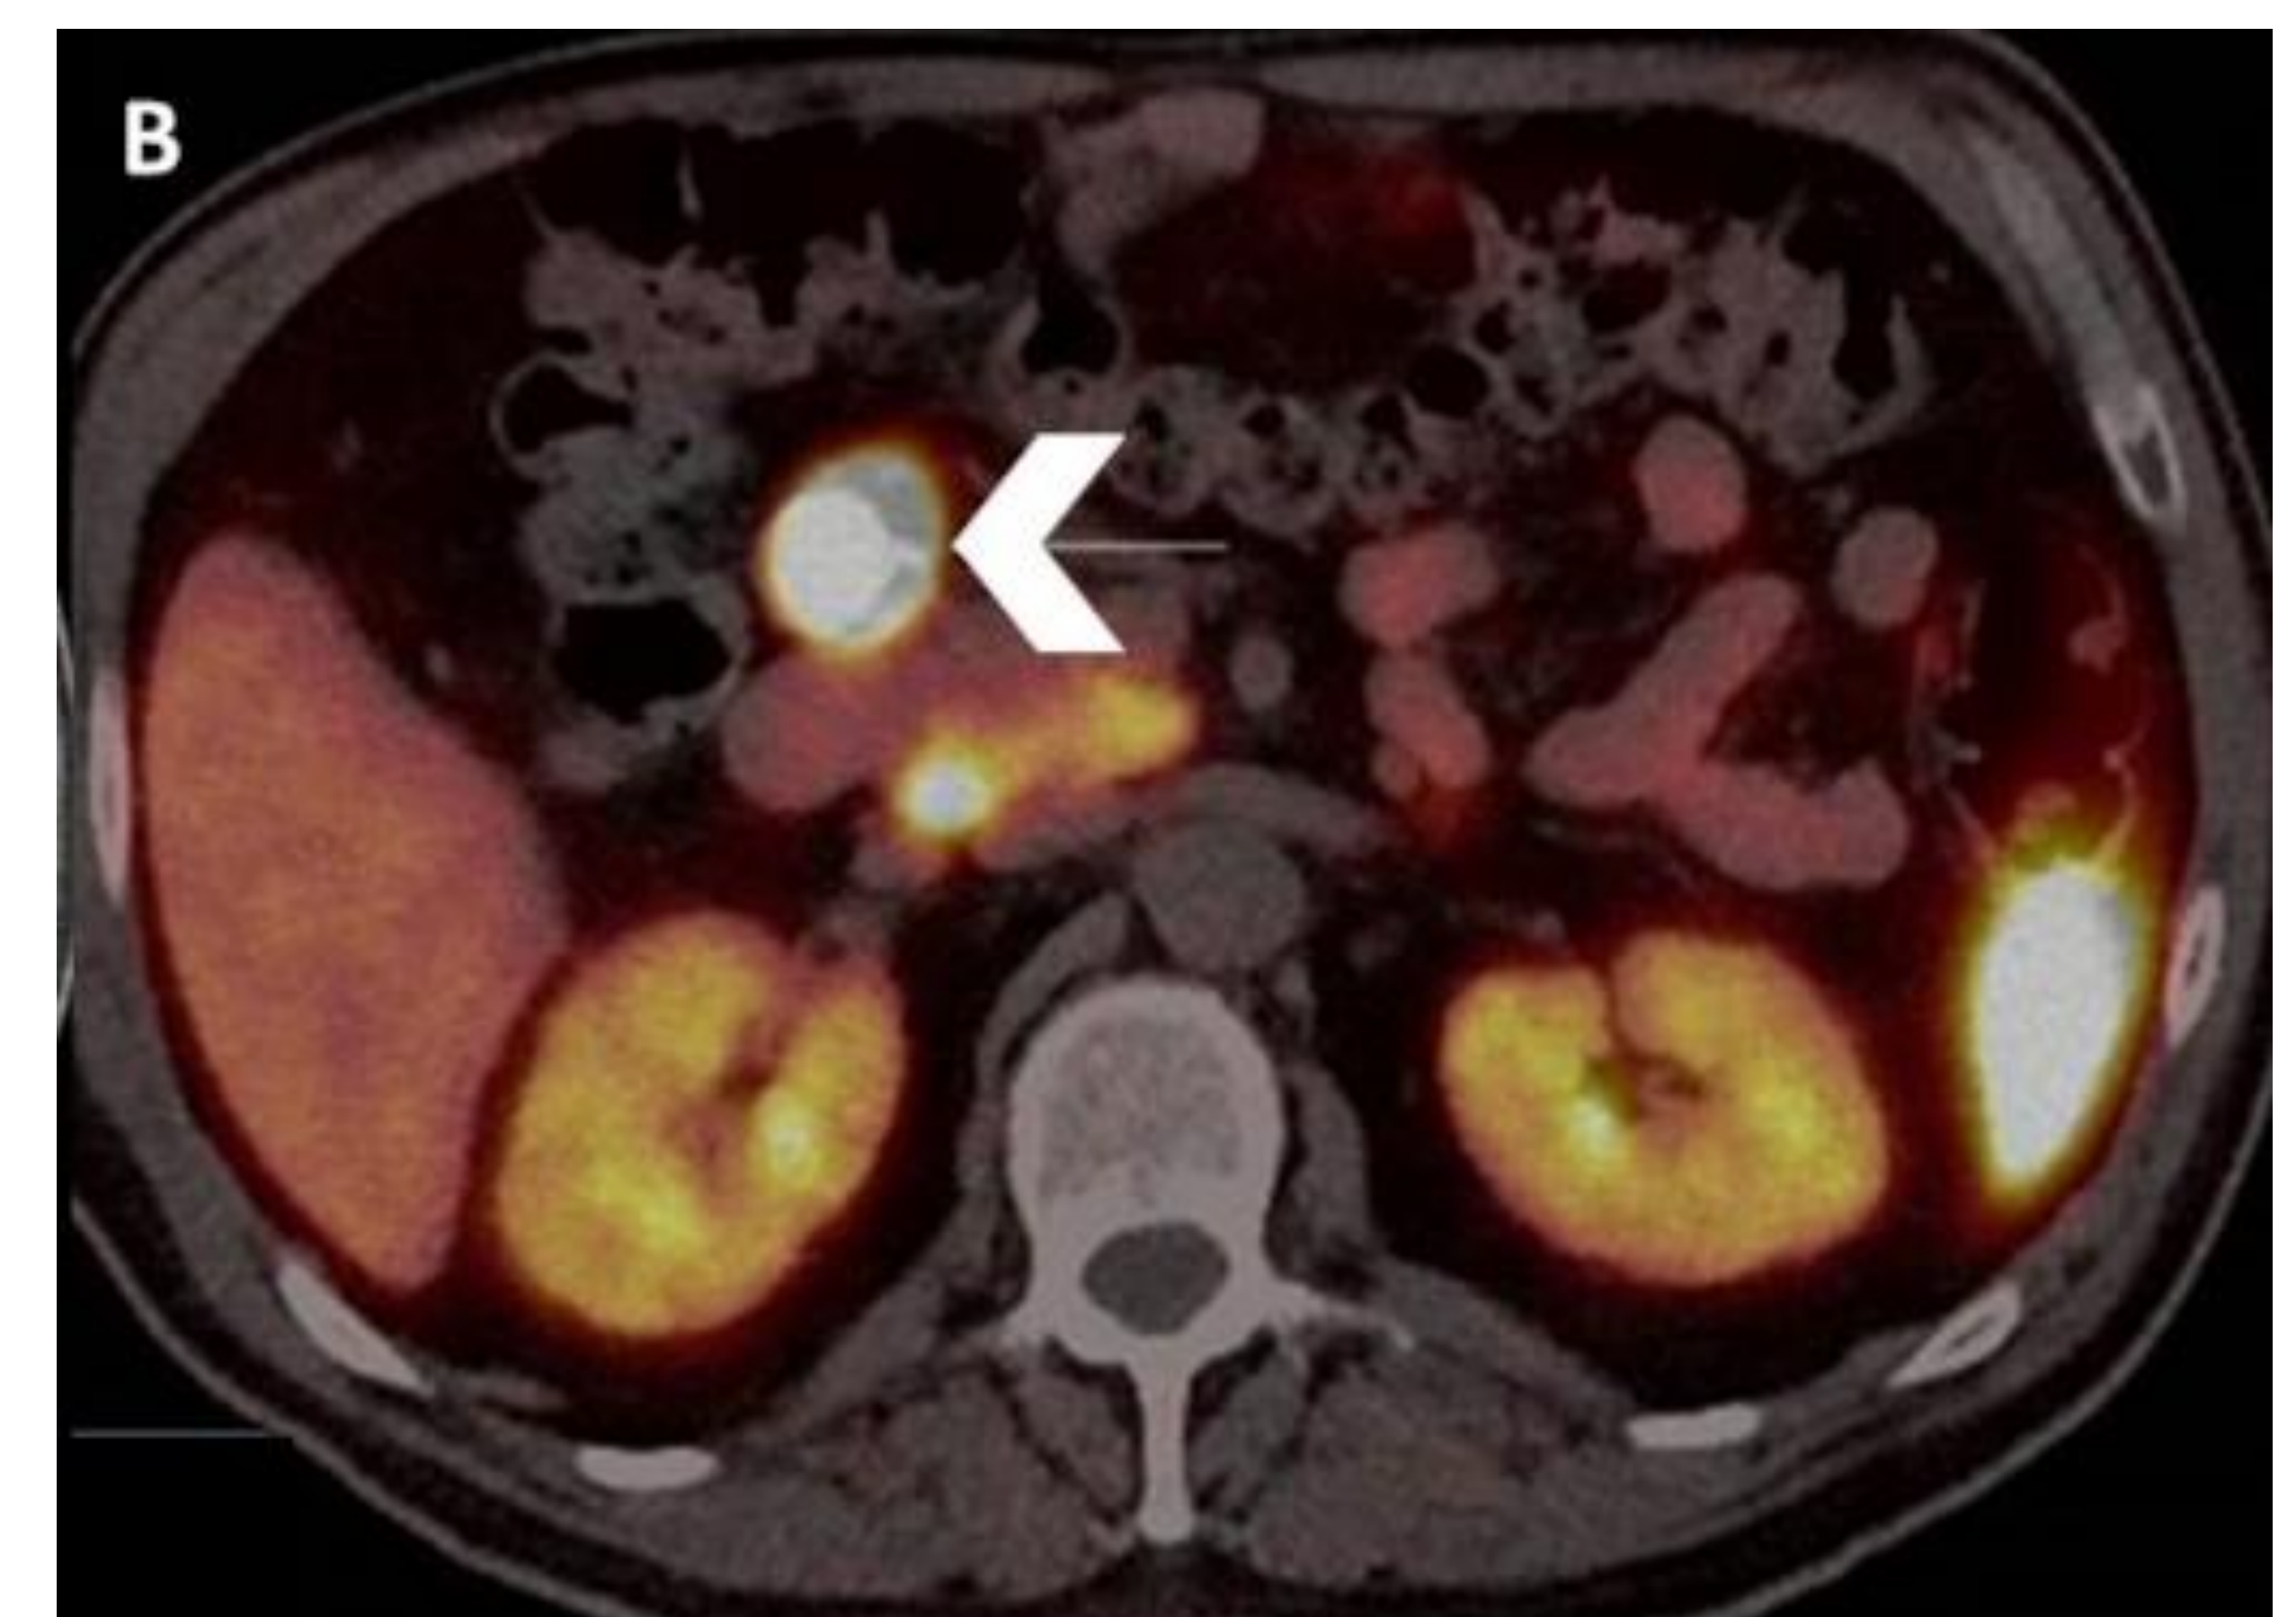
(B): Ga-68 DOTATOC PET/CT scan showing somatostatin receptor-positive peripancreatic node (chevron)
